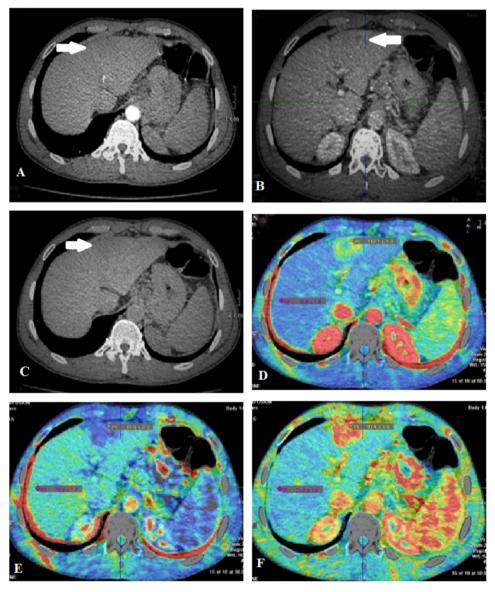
Triphasic CT examination shows (A) arterial, (B) venous and (C) delayed phases for segment II post-RFA ill defined hypodense lesion with no significant contrast uptake in arterial phase, faint peripheral uptake in venous phase and washout of contrast in delayed phase (inconclusive). CTP in axial planes shows a fairly defined left lobe segment (II) focal area with high (AF) in (D), low (PF) in (E) with high (PI) in (F) in relation to the surrounding hepatic parenchyma. Diagnosis: peripheral active neovascularization with suspected tumoral activity (recurrence/residual) in left hepatic lobe HCC after RFA.
